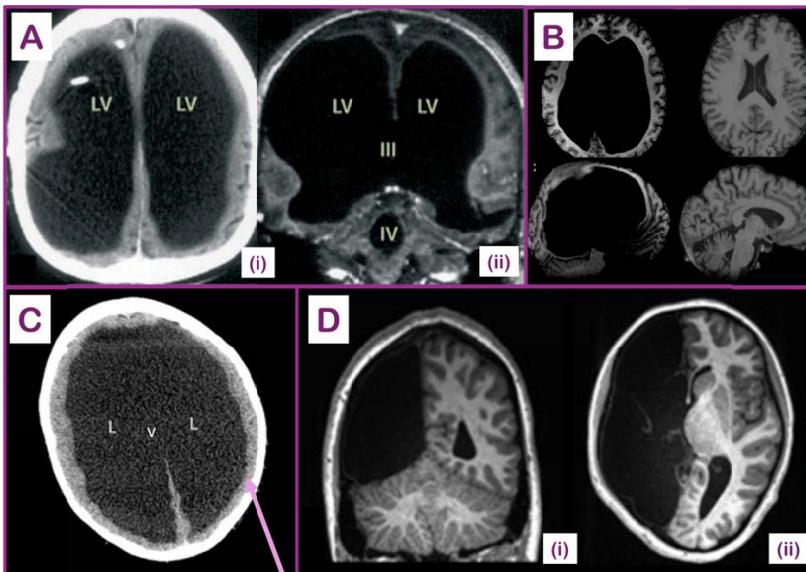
Select cases of reductions in brain matter with normal function. (A) Image from Feuillet *et al.* (2007) showing a white collared worker case of extreme hydrocephalus; he led a normal life as a civil servant with an average IQ of 75. During his neurological assessment at age 44, his (i) CT scan and (ii) T1 weighted MRI scans with contrast showed extreme ventricular enlargement. LV indicates lateral ventricle, III and IV indicate the third and fourth ventricles, respectively. (B) Image from Alders *et al.* (2018), showing the case of a 60-year-old with a bad mood with massive ventriculomegaly and severely reduced cerebral mantle and corpus callosum, that went largely unnoticed. The left column is T1 weighted MRI images taken in the transverse, coronal, and sagittal planes of the patient. The right column represents T1 weighted MRI scans of a healthy control. (C) Image from Persad *et al.* (2021) of a Canadian living a normal, independent life with massive hydrocephaly. MRI scan taken from the axial view (plane parallel to the ground) at the level of the lateral ventricles (arrow points to extremely thin layer of cortical mantle, LV stands for lateral ventricle). (D) Image from Asaridou *et al.* (2020), showing the T1 weighted MRI scans of a child born without left hemisphere taken (i) in the coronal plane and (ii) in the axial plane. The child had normal cognitive development and language skills despite hemihydranencephaly of the left hemisphere and near-absence of the corpus callosum. All images re-used with permission.
